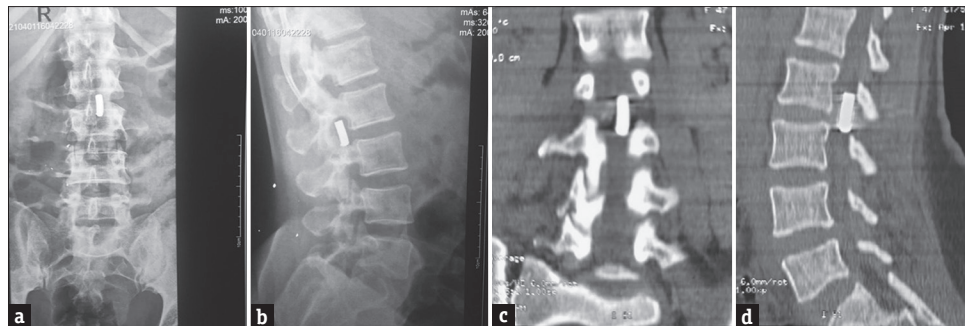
(a) Anterior-posterior lumbosacral spine x-ray of patient at presentation showing a left-sided L2/3 bullet. (b) Lateral lumbosacral spine x-ray of patient at presentation showing a bullet lodged at the L2/3 neural foramen. (c) A coronal lumbosacral spine CT scan of the patient on admission showing a left-sided L2/3 bullet. (d) Sagittal lumbosacral spine CT scan of the patient on admission showing a bullet in the spinal canal at L2/3
